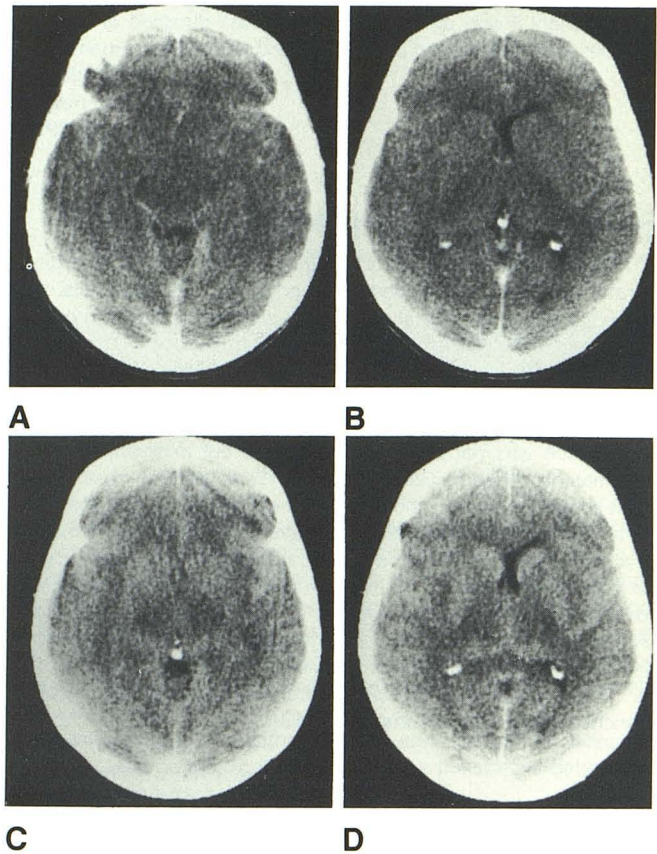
A and B, Cranial CT scans on admission. Small lateral ventricles suggest generalized brain swelling. Pineal gland occupies its normal position in superior part of quadrigeminal cistern, forming a triangle with glomera. C and D, 3 days after admission. Complete effacement of superior quadrigeminal cistern with widening of both internal capsules and diminished density of both thalami. Pineal gland is now in lower quadrigeminal cistern area, indicating inferior displacement.
